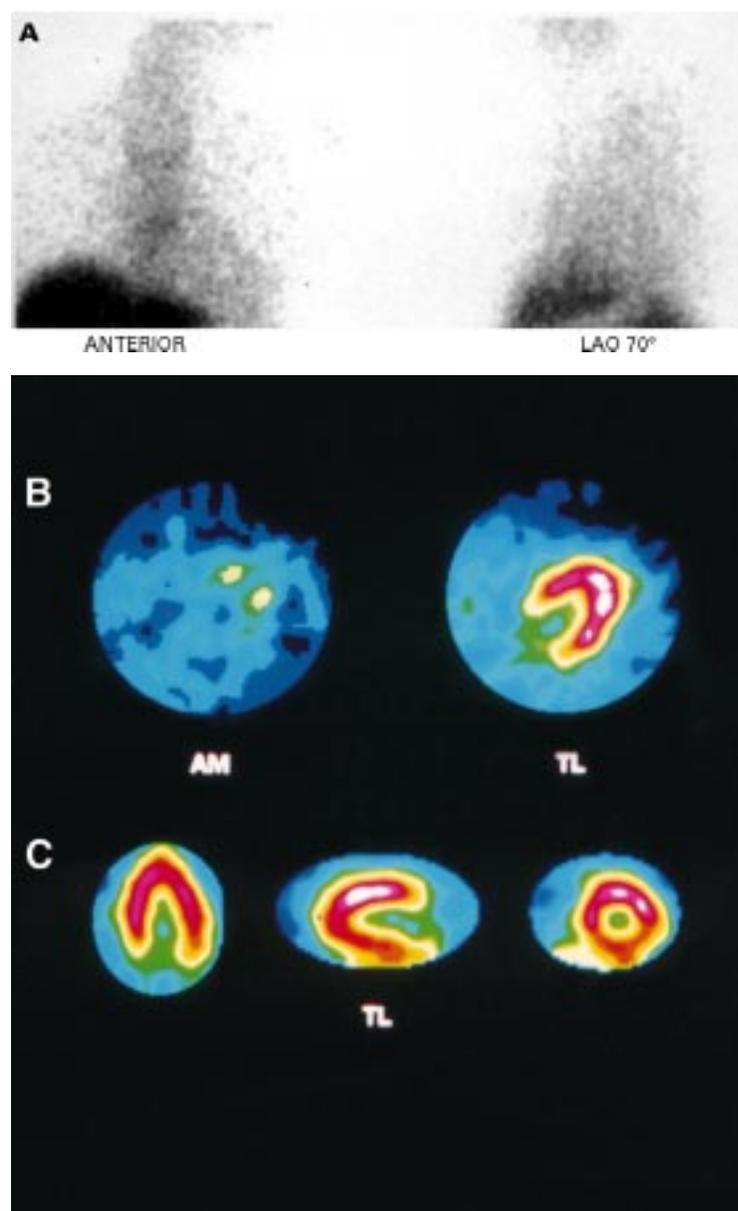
Delayed scintigraphy in patient X at six months. The cardiac manifestations have disappeared, and LV ejection fraction has increased to 41%. There is no more myocardial AM uptake on the planar anterior view (A), HLR=1.7), or on SPECT images (B): corresponding AM/TL slices). TL SPECT is normal (C).
